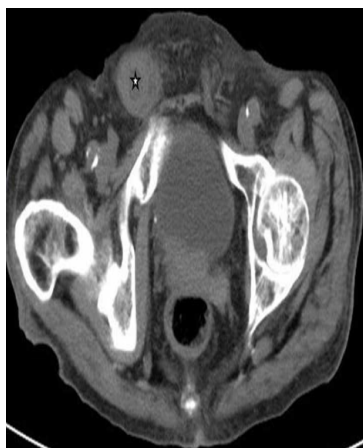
Abdominal CT image without contrast showing a soft tissue mass-like and heterogeneous lesion (asterisk) with a central lower signal in the right inguinal area.
